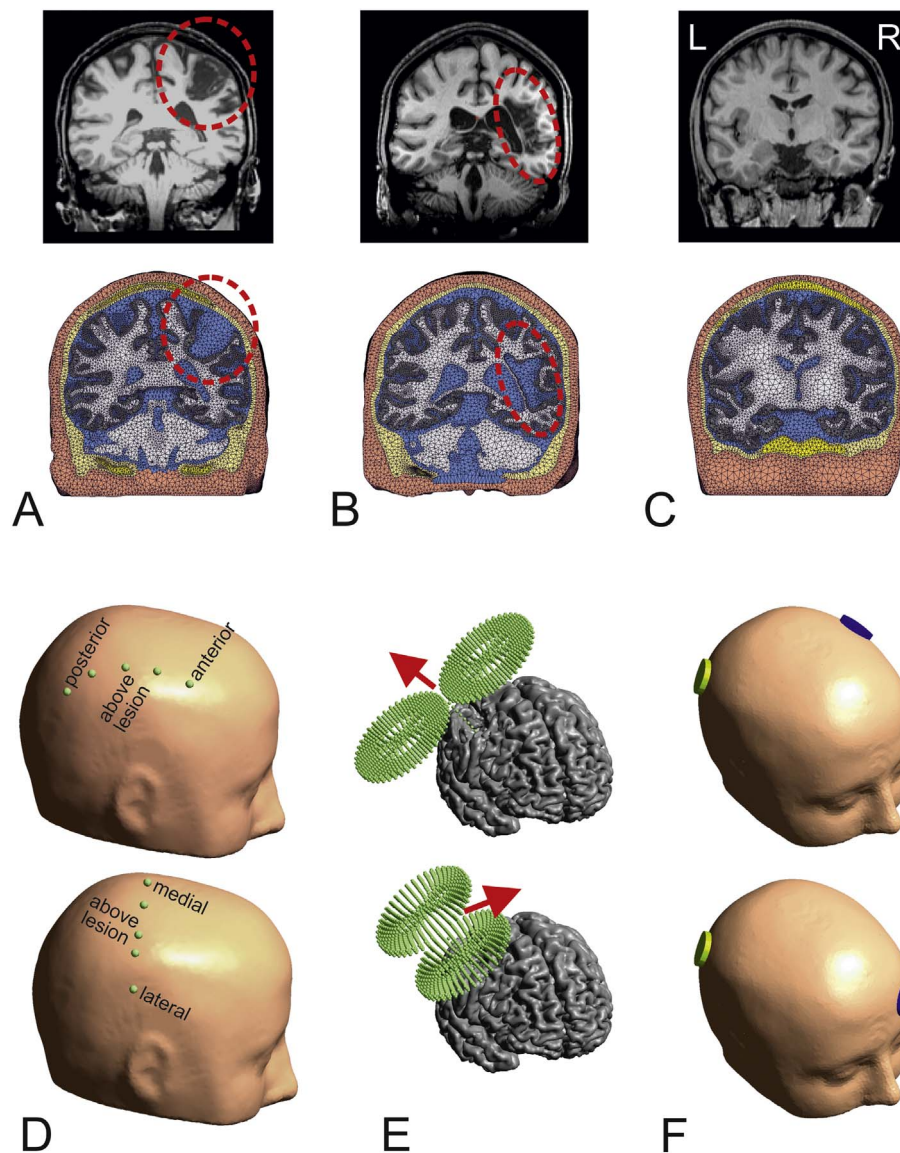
A) Coronal view of patient P01 with a cortical lesion in the right hemisphere. The top shows the T1-weighted MR image and the bottom the reconstructed head mesh. The view was chosen to include the lesion centre. The lesion is marked by red dashed circles. B) Corresponding view of patient P02 with a large subcortical lesion at a similar location in the right hemisphere. C) Corresponding view of the data set of the healthy control. D) The coil and electrode positions were systematically moved along two directions that were approximately perpendicular to each other. Five positions were manually placed every 2 cm in posterior – anterior direction symmetrically around the centre of the cortical lesion. The same was repeated along the lateral – medial direction. Both lines share the same centre position above the lesion, resulting in 9 positions in total. E) At each position, two coil orientations were tested which resulted in a current flow underneath the coil centre from anterior to posterior (top) and from lateral to medial, respectively (bottom). F) For each position of the yellow “stimulating” electrode, two positions of the blue return electrode were tested. First, the contralateral equivalent of the electrode position above the centre of the cortical lesion was used (top). In addition, a position on the contralateral forehead was tested (bottom).
